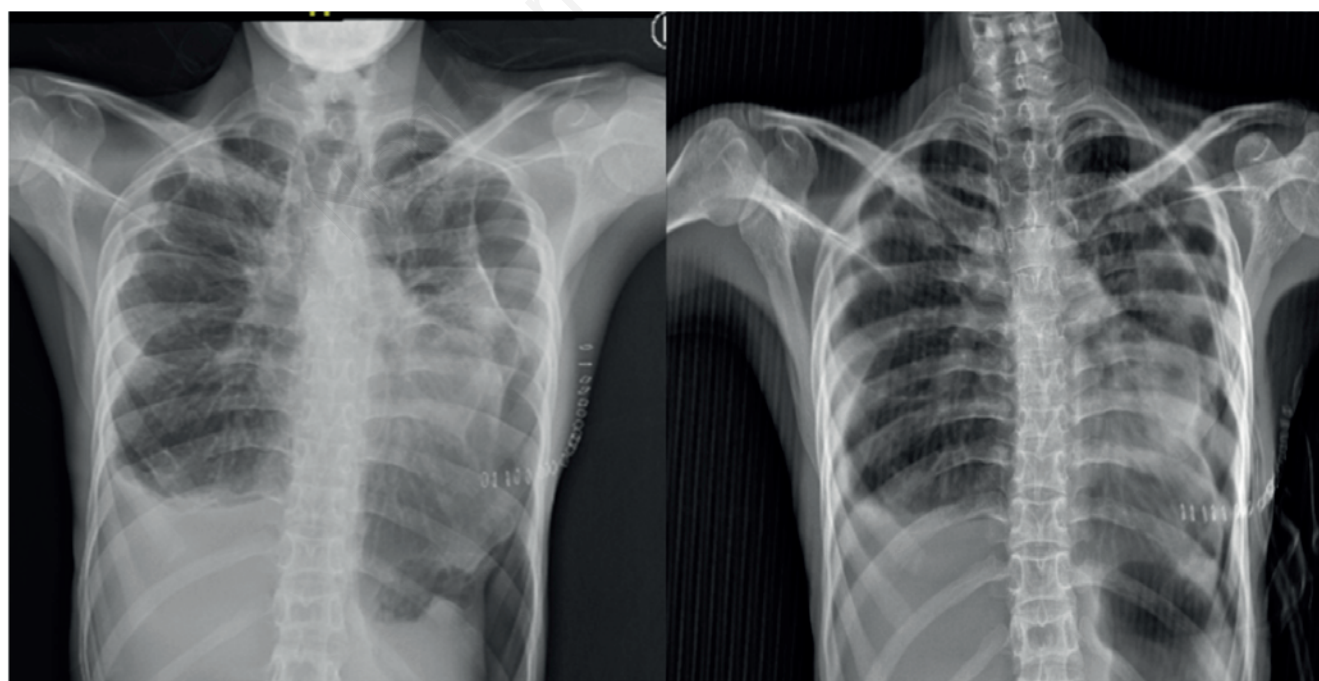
Chest radiograph posteroanterior view postoperatively, showing left side pneumothorax (left panel) and non-expansion of lung post-tube thoracostomy (right panel).
